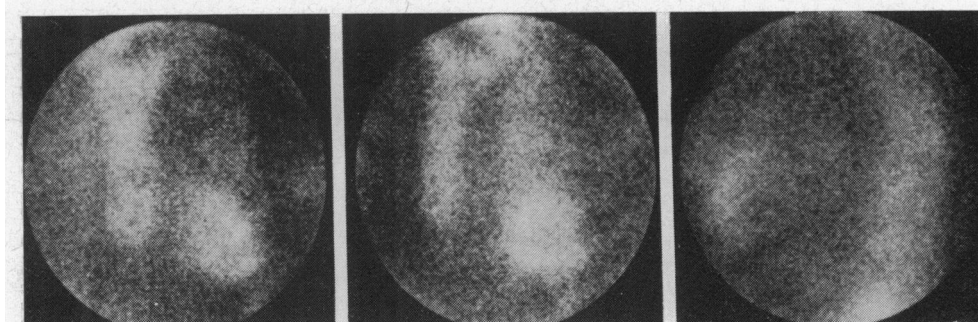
A ^{99m}Tc -PYP myocardial scintigram that shows an anterior and apical myocardial infarction. The three views are the same as in the preceding figure. Note the increased uptake of the ^{99m}Tc -PYP in the anterior and apical regions of the heart.
